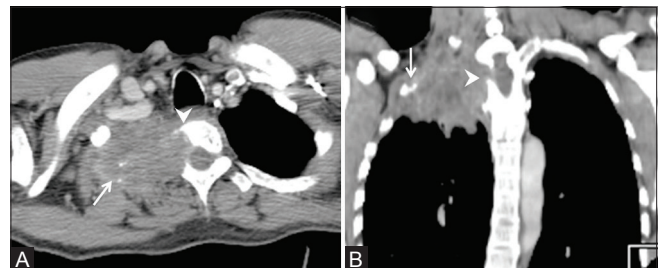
(A and B): Superior sulcus tumor. Axial (A) and coronal (B) CT scans show a large mass in the apex of the right lung causing destruction of the first and second ribs (arrows) with erosion of the right half of the vertebral body (arrowheads) suggestive of a superior sulcus tumor
